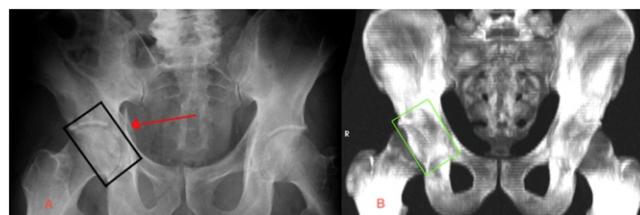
X-ray image of the pelvis (A) in the coronal view with a rectangular region indicating the femoral head, acetabulum and the articular cartilage ("Acetabular fracture as seen on plain X-rays" by James Heilman, MD is licensed under CC BY-SA 3.0/Modified from original). OsiriX 3D MIP (B) in the coronal view with a rectangular region designated with the scissor tool to indicate the hip joint ROI. The X-ray image is shown here as a reference to explain how the boundaries of the rectangular region in the 3D MIP were decided.
